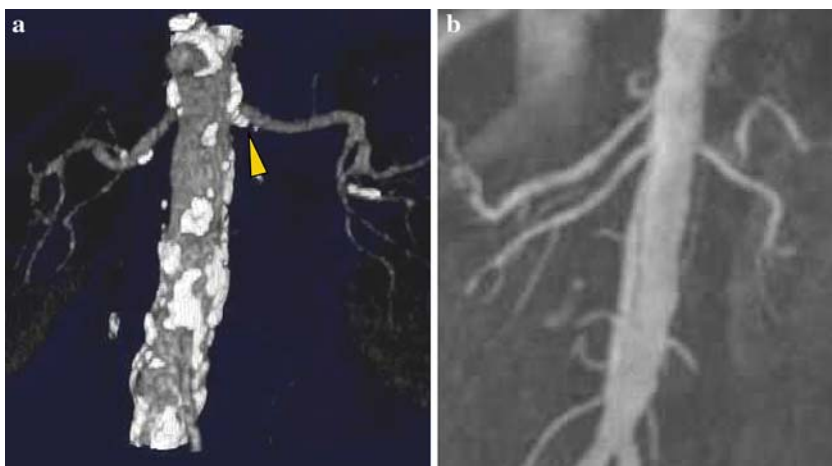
Atheromatous calcification in the abdominal aorta and at the renal ostia. CTA and MRA of the abdominal aorta and renal arteries in the same patient. A CTA with extensive atheromatous calcification throughout the abdominal aorta and at the origin of the left renal ostia (*arrowhead*). B MRA shows luminal opacification which is unobscured by atheromatous calcification.
